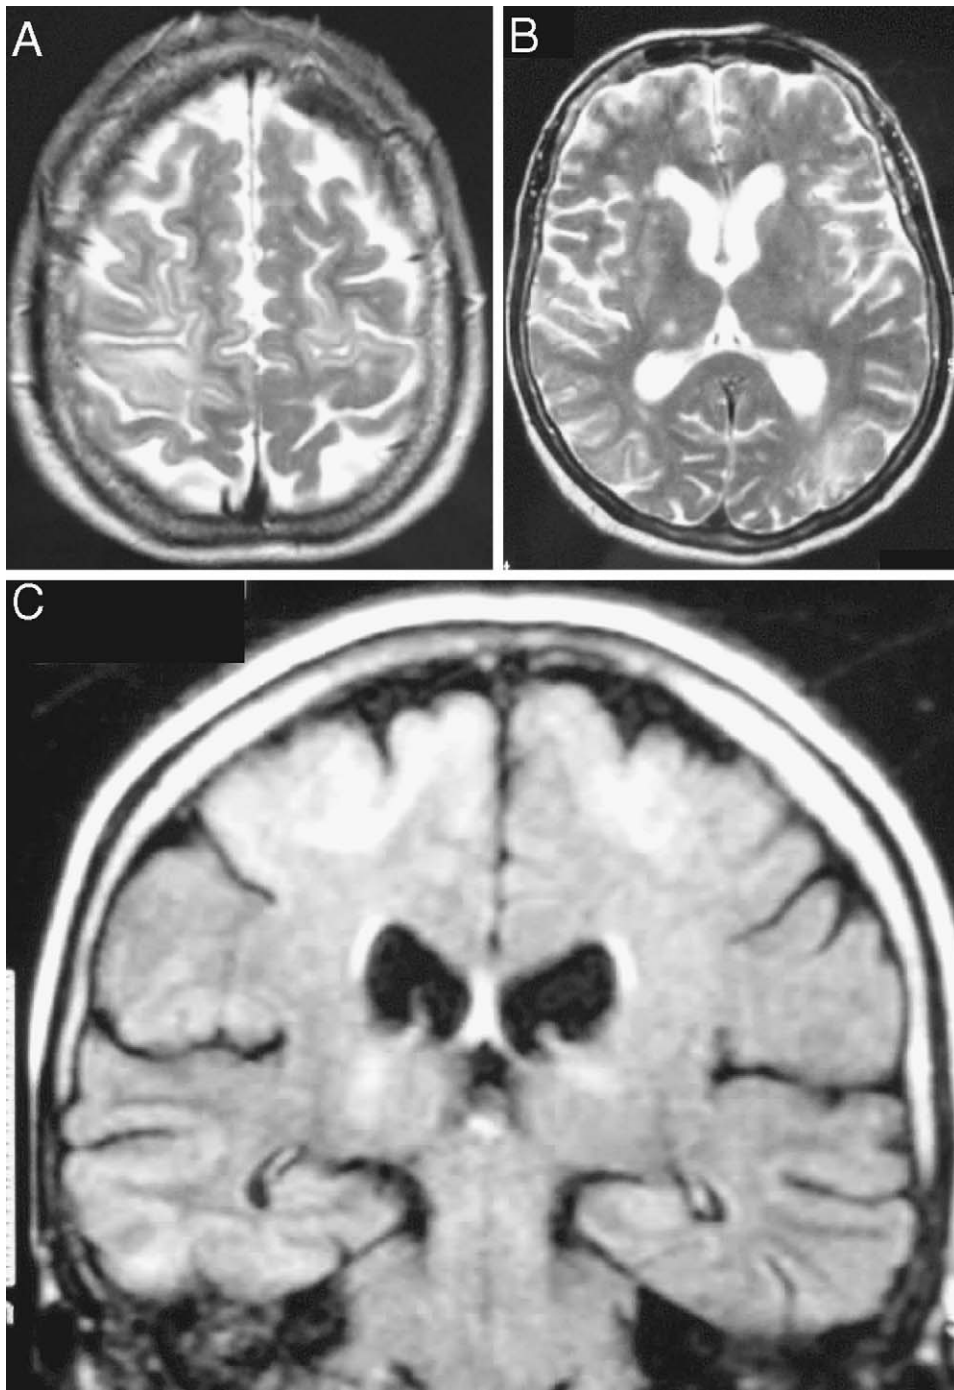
(A, B) Axial T2-weighted brain magnetic resonance images (MRI) showing hyperintensities in frontal and parietal subcortical areas and thalamic nuclei, bilaterally. (C) Coronal flair sequences showing hyperintensities at the level of cortical-subcortical junction and basal ganglia.
